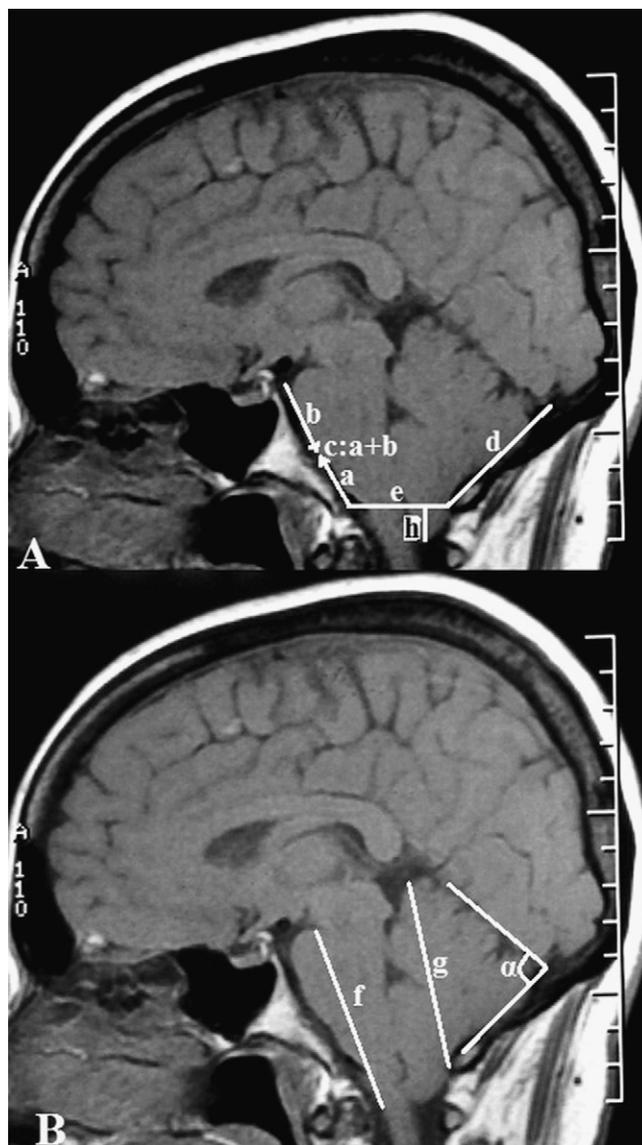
T1-weighted sagittal MR image showing the midline structures of the posterior cranial fossa and the brainstem and cerebellum. (A) a: Length of the basiocciput between the sphenooccipital synchondrosis and the basion; b: length of the basisphenoid between the top of the dorsum sellae and the sphenooccipital synchondrosis of the clivus; c: length of the clivus (a + b); d: length of the supraocciput between the internal occipital protuberance and the opisthion; e: the anteroposterior diameter of the foramen magnum from the distance of the McRae line between the basion and opisthion; h: degree of tonsillar descent from the McRae line; (B) f: length of the hindbrain midbrain-pons junction and the medulloccervical junction; g: length of the cerebellar hemisphere; α : angle of the cerebellar tentorium.
